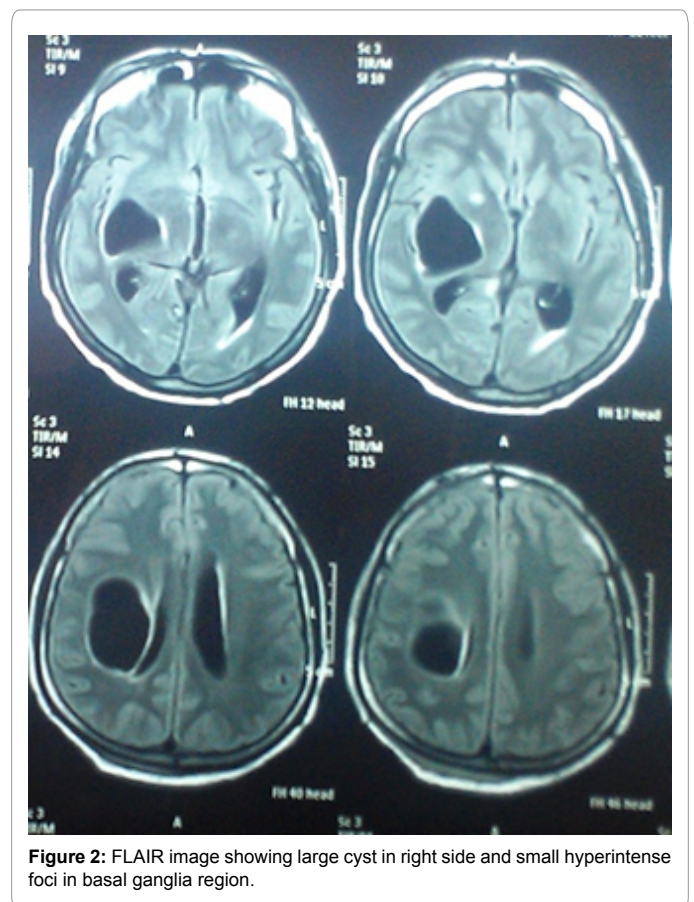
FLAIR image showing large cyst in right side and small hyperintense foci in basal ganglia region.
